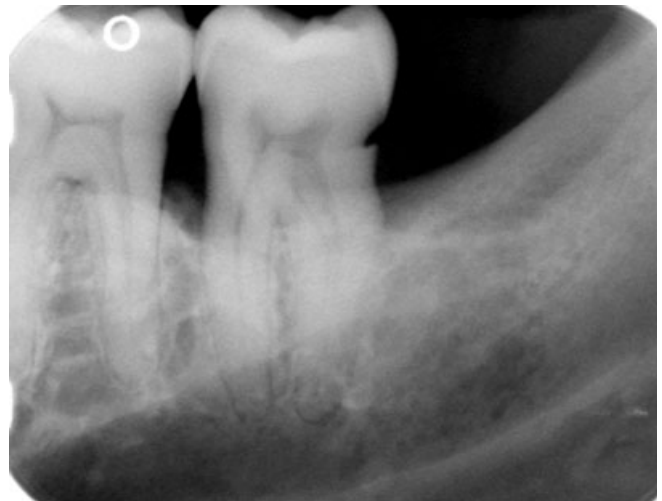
Radiograph of mandibular left 2nd molar (no. 18) showing 'V'-shaped notch-like defect on distal surface.
